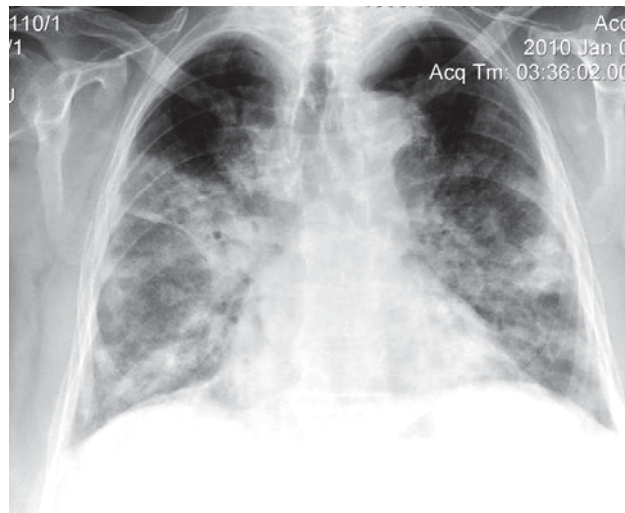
Initial chest radiography of a patient with acute respiratory distress syndrome (ARDS) caused by Influenza A (H1N1)
